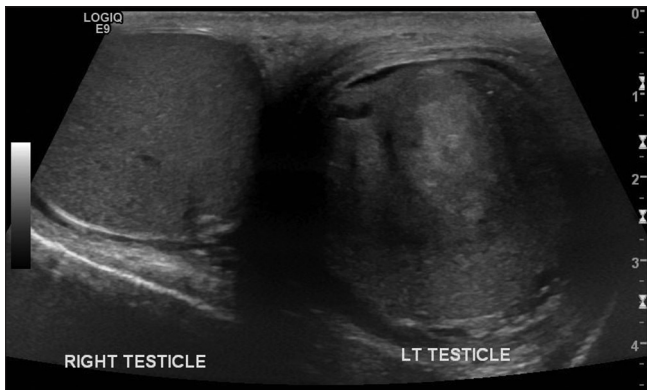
Testicular ultrasound showing heterogenous mass in the left testicle
